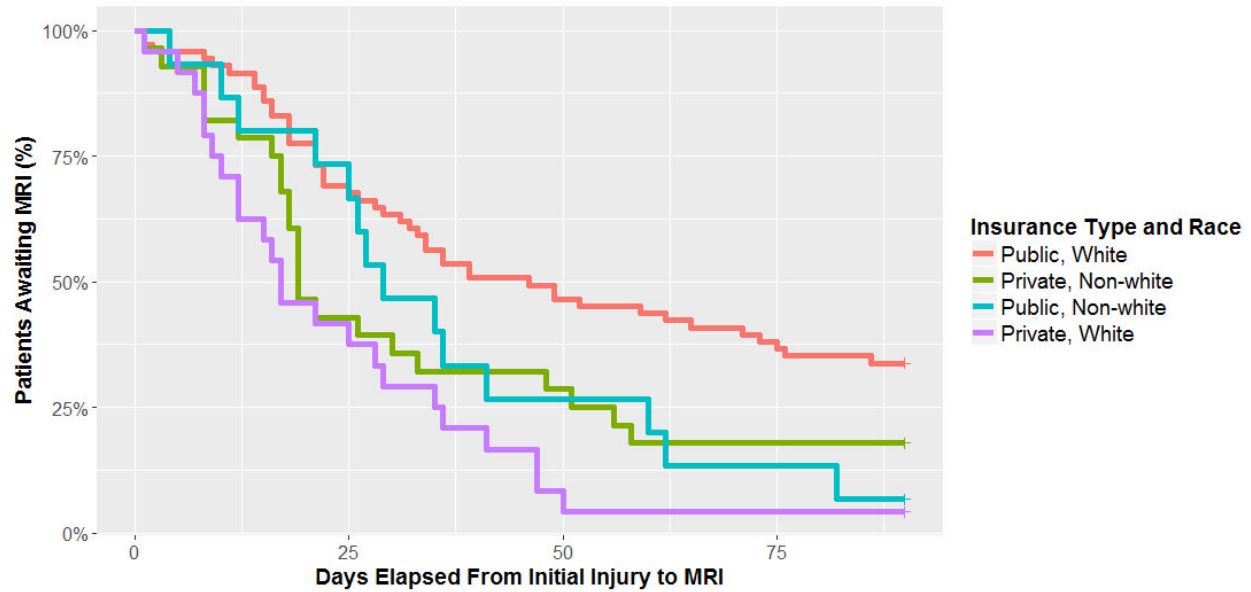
Time from Injury to MRI Stratified Based on Insurance and Race
